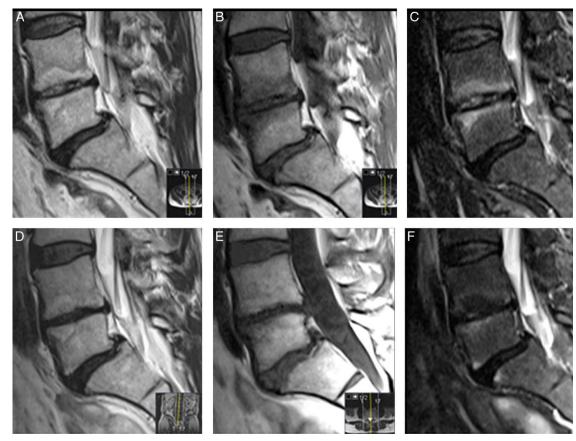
Examples of reduced MC edema. A–F, Example of MC edema at L4/L5. Baseline MRI showing MC edema with high T2 signal (A), low T1 signal (B) (*i.e.*, MC1), and high signal on STIR (C). One-year MRI shows unchanged T2 signal (D) and higher signal with a hyperintense area on T1 (E) (*i.e.* reduced area of the type 1 part of the MC) and reduced area and intensity of the high signal on STIR (*i.e.* reduced MC edema on STIR) (F). MC indicates Modic change; MC1, MC type 1; MRI, magnetic resonance imaging; STIR, short tau inversion recovery; T1/T2, T1-weighted/ T2-weighted. full color
